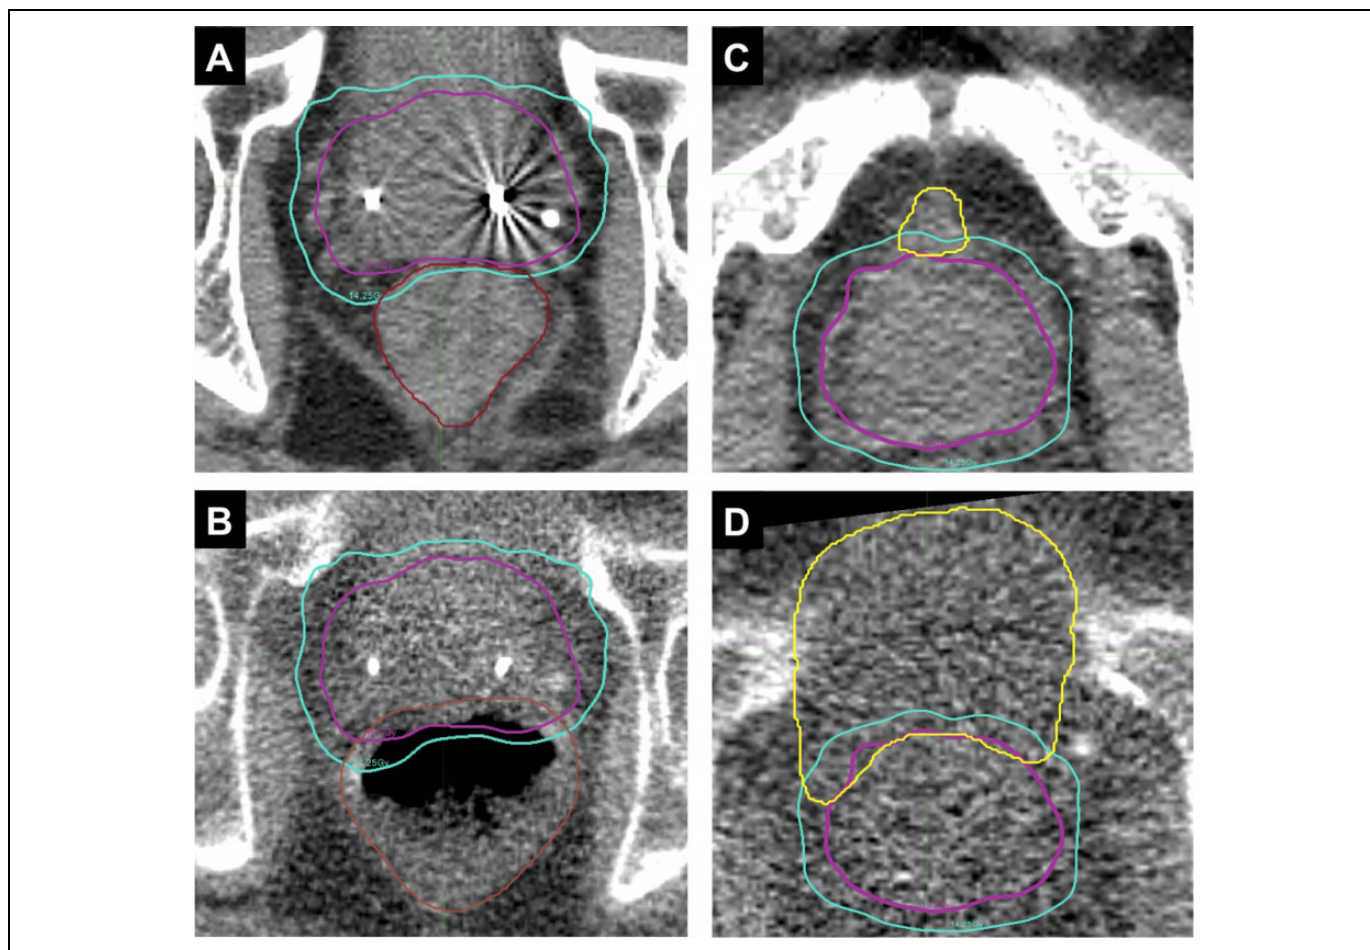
Rectal and bladder contours on planning computed tomographies and daily megavoltage computed tomographies (MVCTs). A, Rectal contour (brown) delineated on CK planning computed tomography (CT) for patient 5. B, Rectal contour delineated on an MVCT acquired during external beam radiotherapy, shown on same slice as (A). C, Bladder contour (yellow) delineated on CK planning CT for patient 1. D, Bladder contour delineated on MVCT acquired during external beam radiotherapy, shown on same slice as (C). For (A) to (D), prescription isodose line (19 Gy) is shown in purple, whereas the 75% isodose line (14.25 Gy) is shown in teal. Note: The color version of the figure is available at journals.sagepub.com/home/tct
